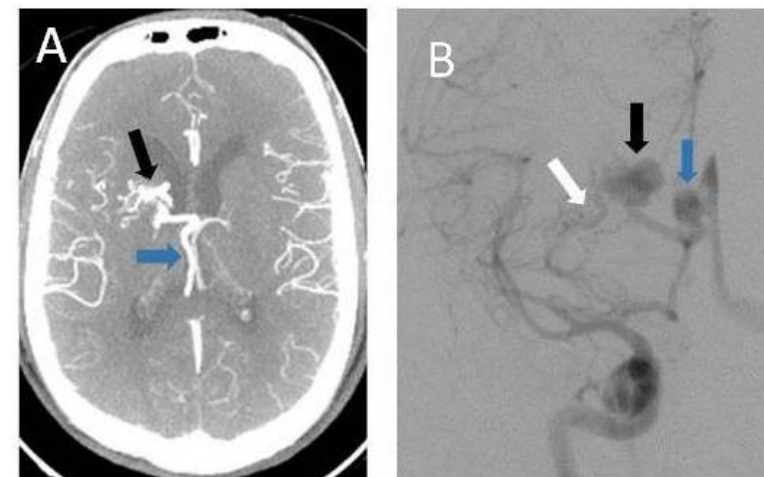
(A) Axial CTA MIP image shows an AVM nidus (black arrow) in the right head of caudate and the draining vein, right internal cerebral vein (blue arrow). The AVM measured 1.7cm.
